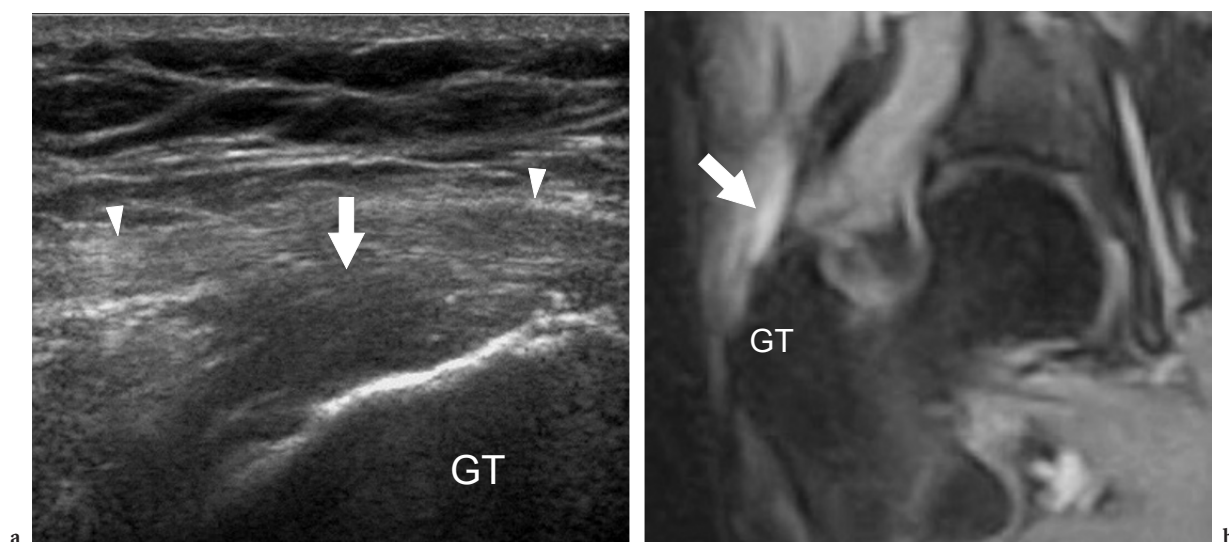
Tendinopathy of the anterior tendon of the gluteus medius. a Coronal 12–5 MHz US image over the greater trochanter (*GT*) shows swelling and a heterogeneous hypoechoic appearance of the anterior tendon (*arrow*) of the gluteus medius. Observe the fasciae latae (*arrowheads*), which appears slightly thickened but without signs of discontinuity. b Corresponding coronal fast-STIR MR image confirms the presence of a swollen and hyperintense tendon (*arrow*) owing to degenerative changes and edema. The greater trochanter (*GT*) displays normal intensity signal
